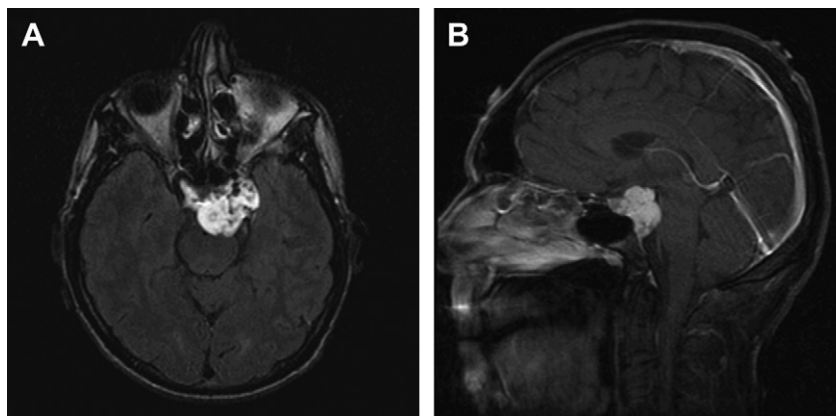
T2-weighted axial FLAIR (A) and T1-weighted contrast enhanced sagittal (B) images of a patient with a skull-base chondrosarcoma centered at the left petroclival junction.
